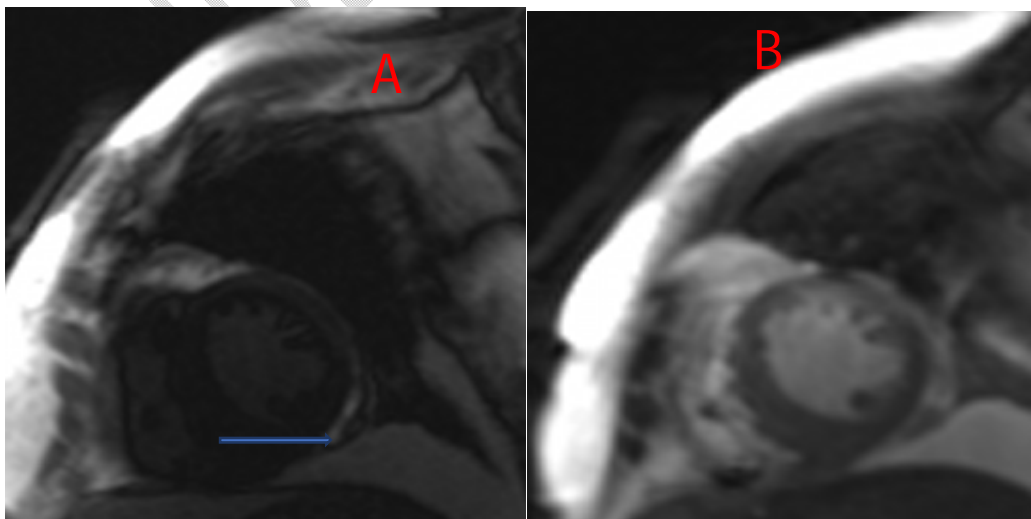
Cardiac MRI: A- T2 hypersignal showing late diffuse epicardial enhancement and onset of myocardial fibrosis (blue arrow). B- Hypertrophy of the left ventricle
